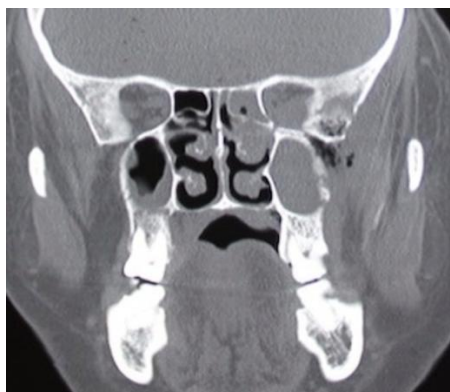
The CT scan showing erosion of superior alveolus on either side, anterior aspect of the hard palate, anterior and lateral walls of the left maxillary sinus extending to the floor of the left orbit including left zygoma, left lesser and greater wings of sphenoid, left medial and lateral pterygoid plates.
